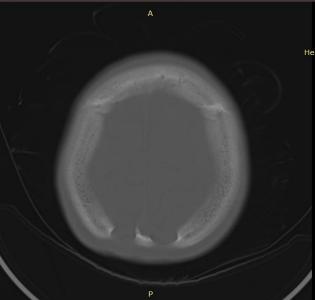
Axial CT image of head (Bone window settings) showing bilateral symmetric round to oval parietal bone defects involving both the inner and outer tables with scalloped sclerotic margins measuring approximately 11mm in diameter.
